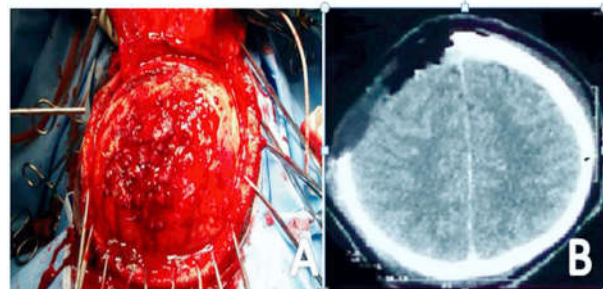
A. Per operative photograph showing bony destruction by tumour. B. Post operative CT showing excision of tumour along with overlying bone.
